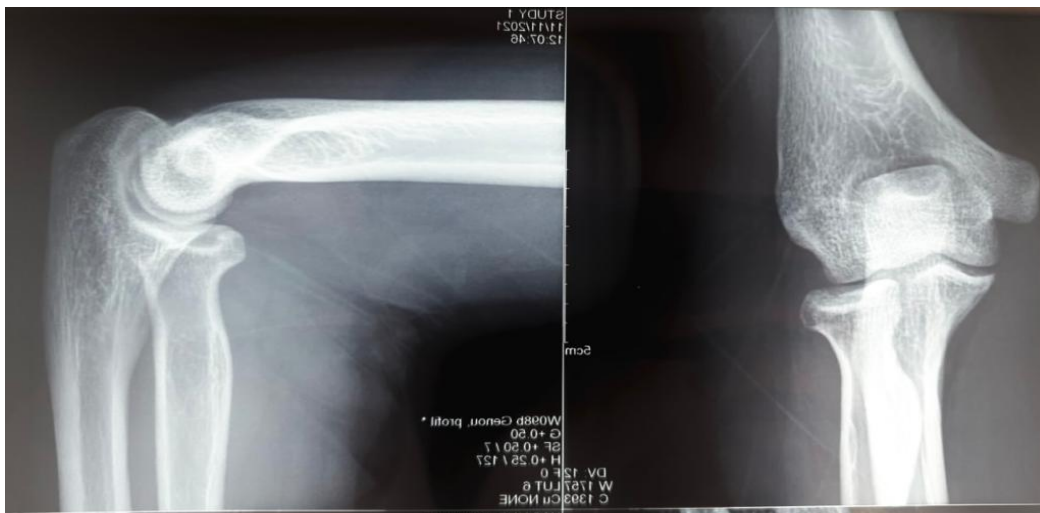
X-ray left elbow face and profile after removal of the plaster and which shows consolidation of the radial head.
